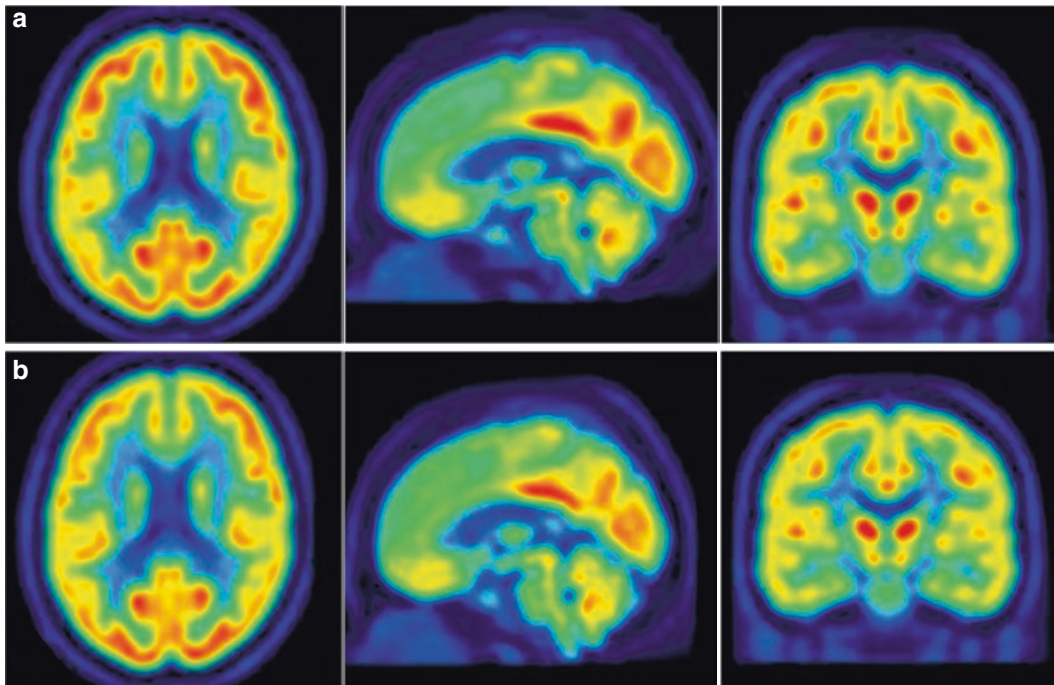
Longitudinal ^{18}F -FDG PET imaging of patients with MCI: ^{18}F -FDG PET imaging of ApoE $\epsilon 4$ non-carriers at baseline and after 72 months (a) shows non-significant decreases in cerebral glucose metabolism. ^{18}F -FDG PET imaging of ApoE $\epsilon 4$ carriers at baseline and after
